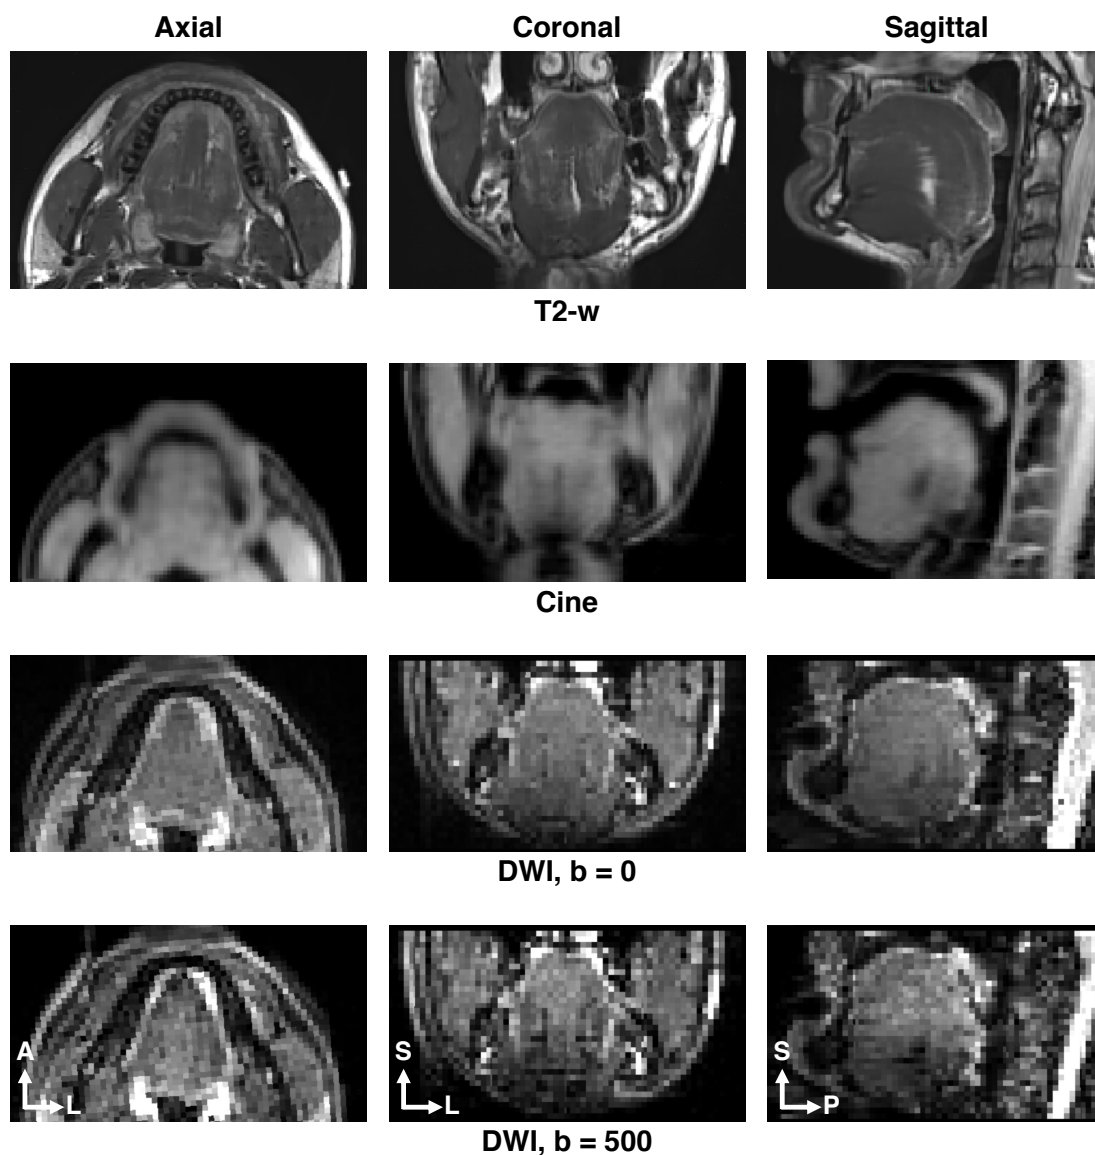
Examples of different MRI modalities from the same tongue data. A = anterior; L = left; S = superior; P = posterior.
